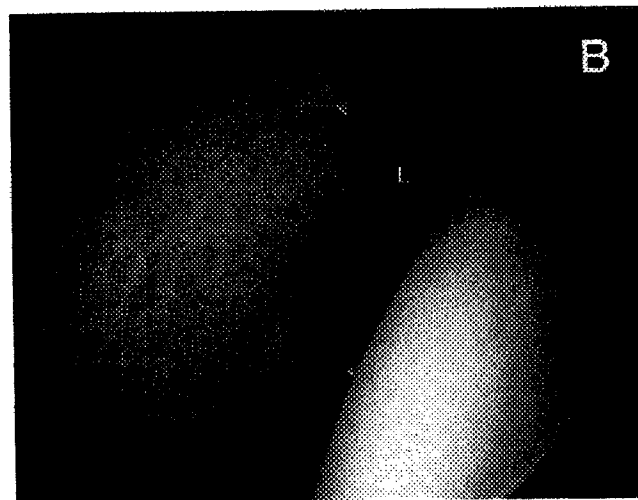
An 18-year-old man with recalcitrant right hip pain following a twisting injury playing basketball. (A) High-resolution MRI was obtained using a shoulder coil shows evidence of tearing in the labrum [Arrow]. (B) Arthroscopic view of the right hip from the posterolateral portal showing the area of traumatic detachment involving the anterior labrum [L]. The presence of granulation tissue [Arrow] highlights the attempted healing response.
